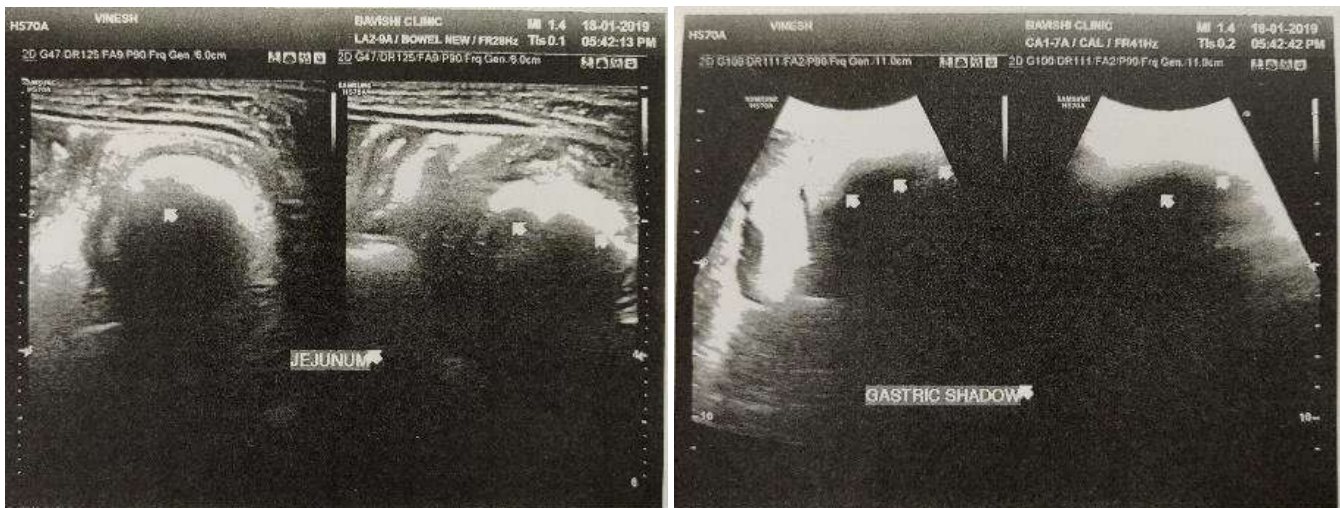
Abdominal Sonography
